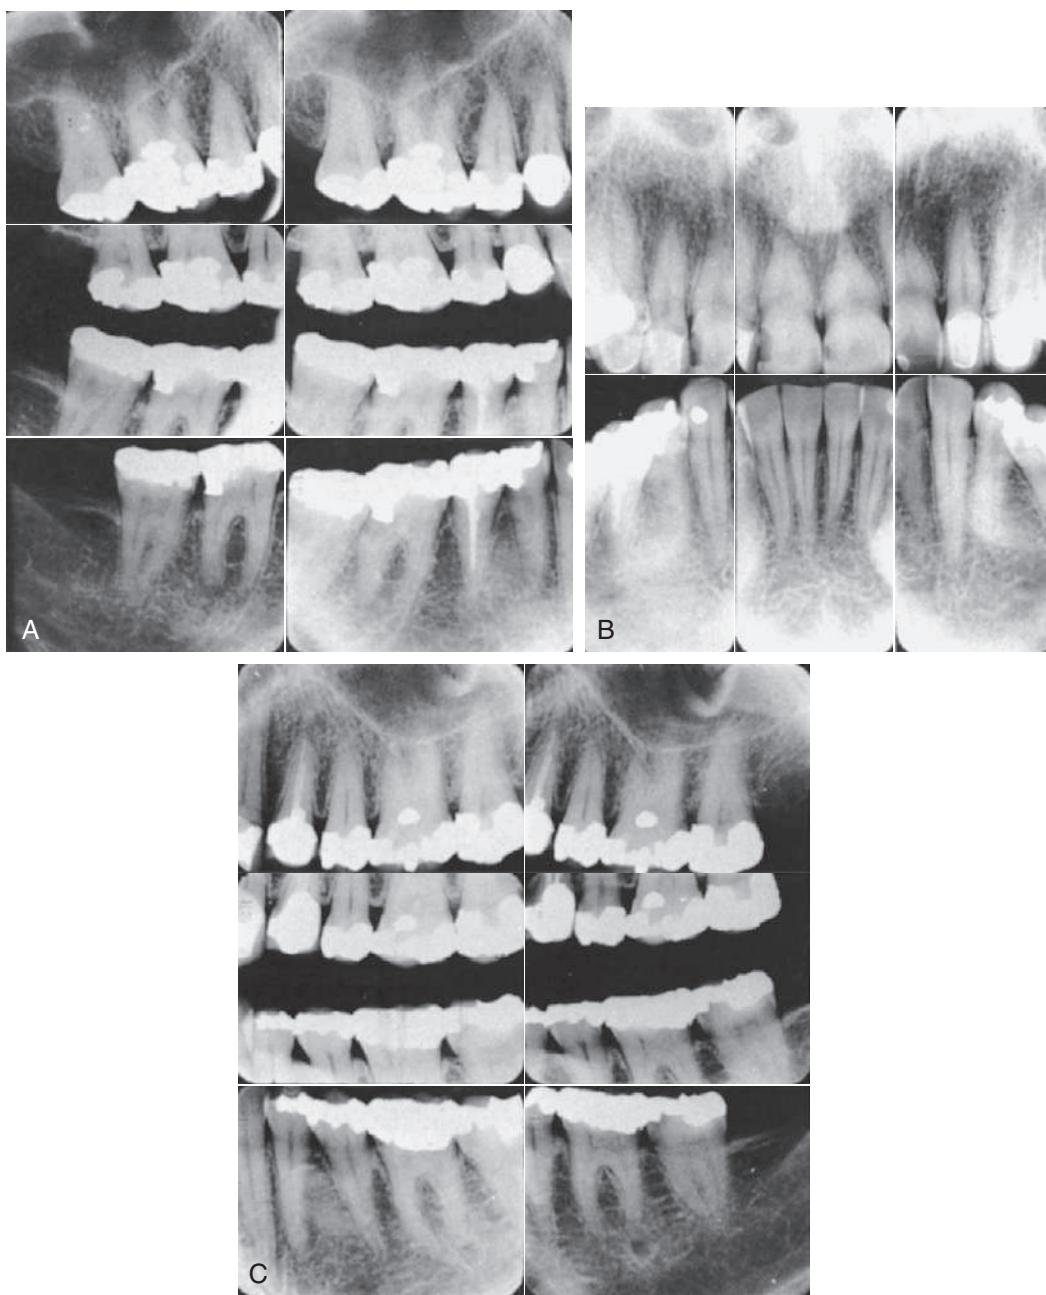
(A–C) A full-mouth radiographic survey should enable the dentist to make a detailed assessment of the structure of each tooth and its bone support.
